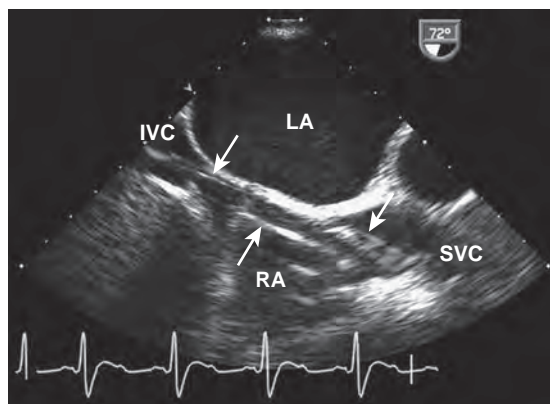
Midesophageal, bicaval, transesophageal echocardiogram demonstrates the venous cannula (arrows), which has been passed through the inferior vena cava (IVC), across the right atrium (RA), and into the superior vena cava (SVC). The left atrium (LA) is visualized at the top of the image.
